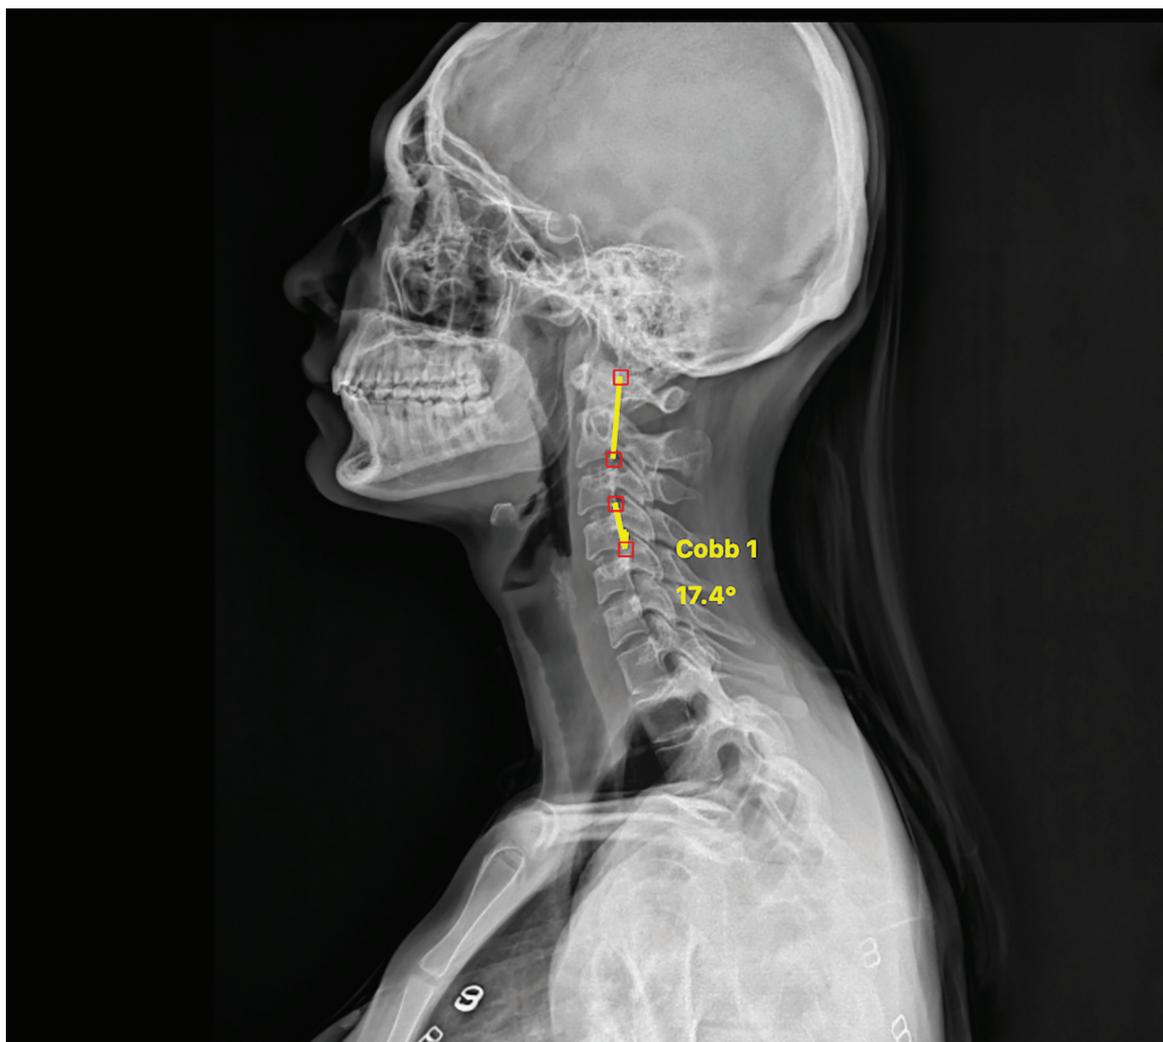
UCL measurement on cervical lateral x-ray (the measurement method is described in detail in the method section).
